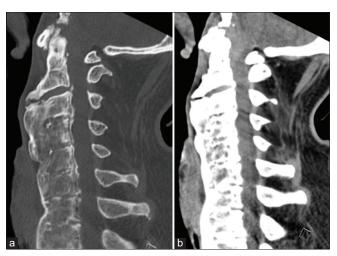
(a and b) CT-image of the craniocervical region showed a severe cervical ankylosis with craniocervical stenosis and with a fracture of the anterior syndesmofyte at the C2-C3 level.
